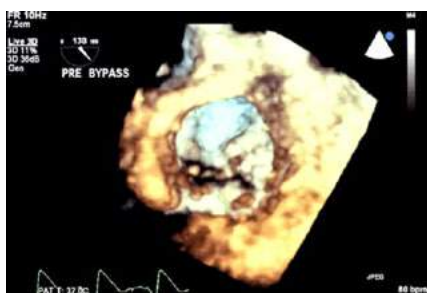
Transoesophageal 3-D echocardiogram showing the anatomy of the mitral valve with incomplete closure of the mitral leaflets due to significant tethering posterior>anterior leaflets.
